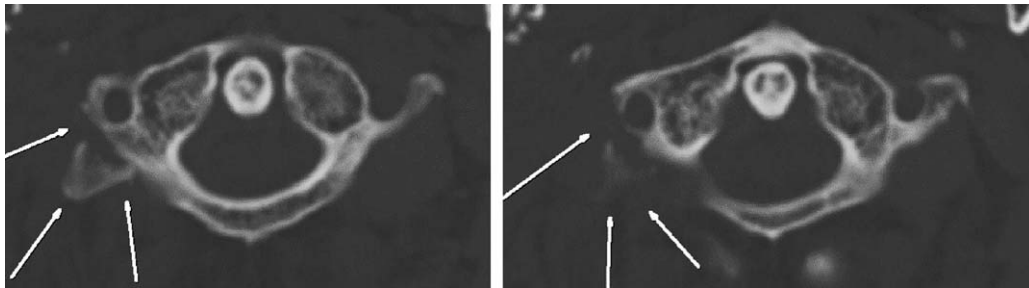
A transverse process fracture of the atlas observed on the cervical-spine CT.
